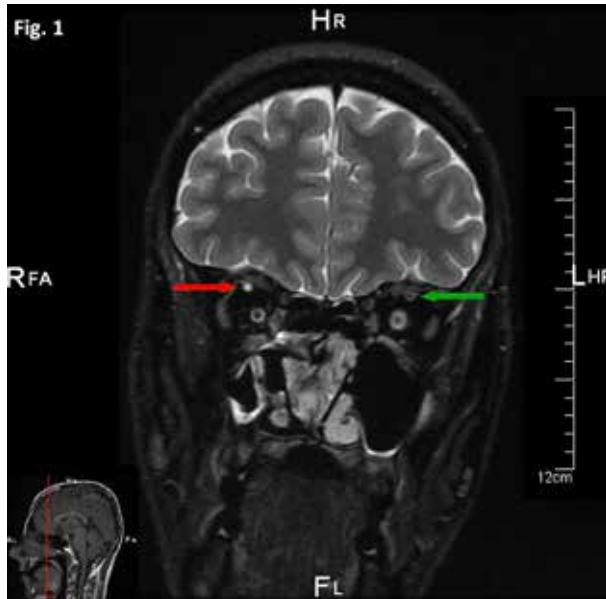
MRI Scan shows obstruction in the vessel on the affected side (red arrow) as compared to the normal vessel as the opposite side (green arrow).
